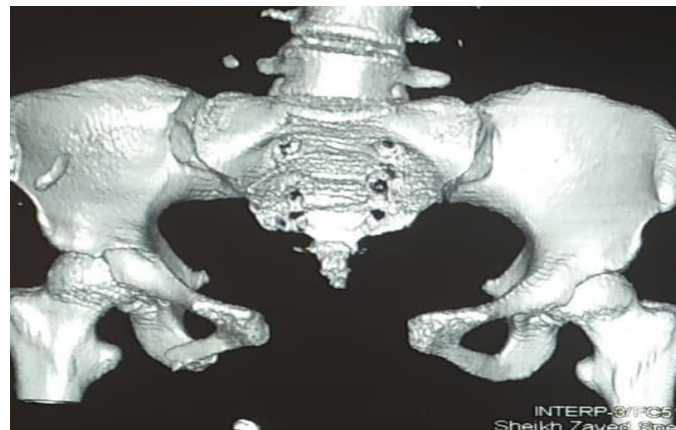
CT reconstruction showing bilateral sacroiliac joint dislocation with symphyseal diastasis.
